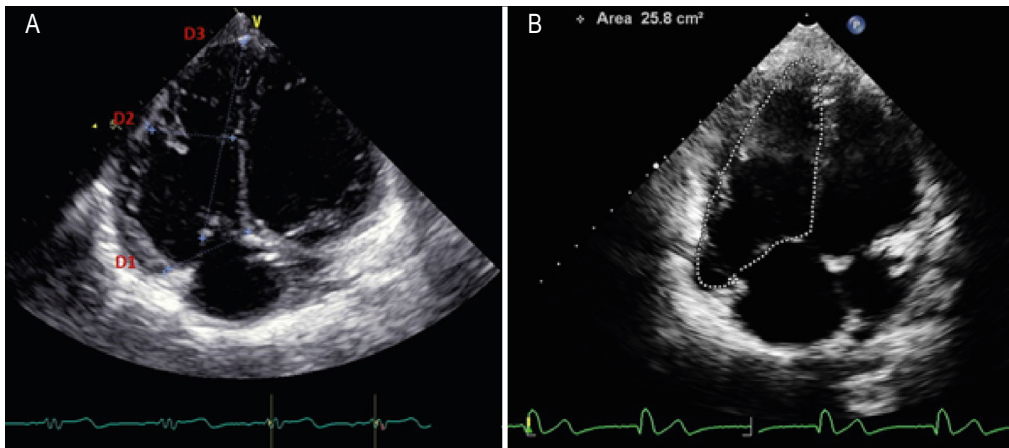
(A) Evaluation of the right ventricle dimensions in the apical four-chamber plane. Basal portion (D1); medial portion (D2); longitudinal portion (D3). (B) End-diastolic RV planimetry.
